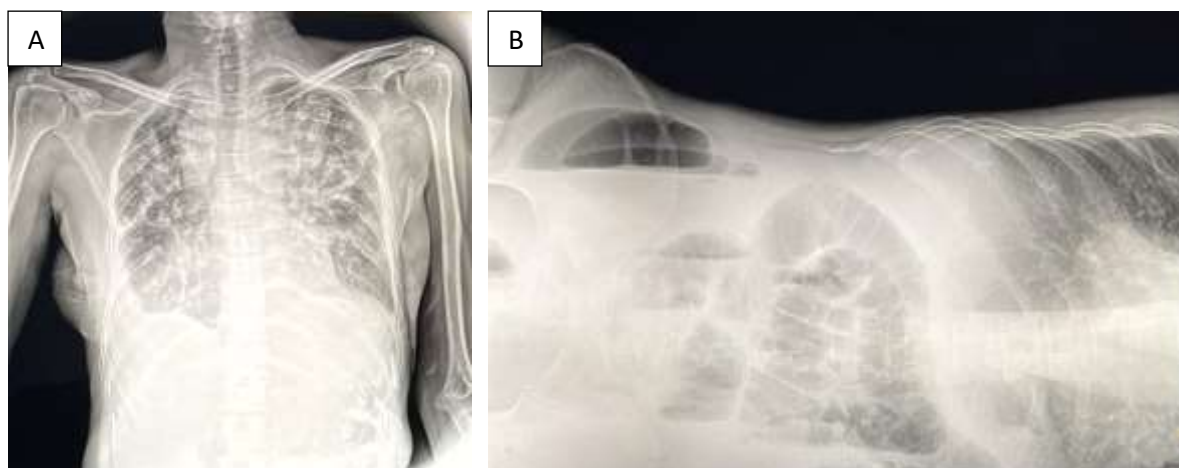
Radiological Examinations (a) Thorax X-ray; (b) BNO LLD Position
